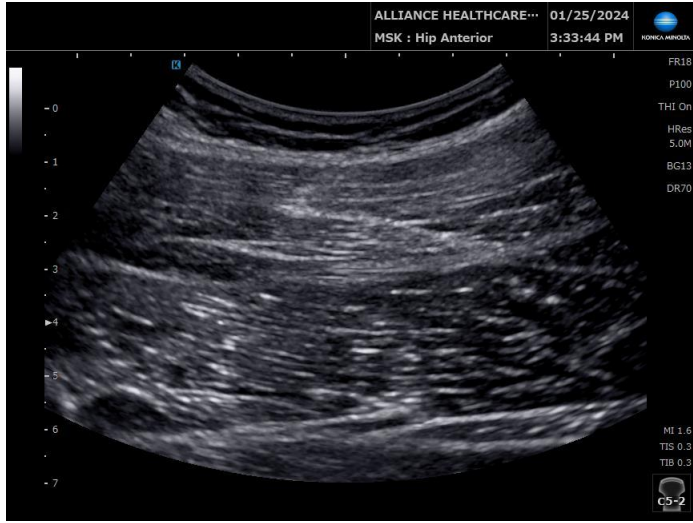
a Short-axis ultrasound view of the proximal third of the back thigh. b By placing the probe in the long axis over the sciatic nerve, the biceps femoris muscle can be located. c By placing the probe in the long axis over the semimembranosus tendon (C), the semitendinosus muscle
